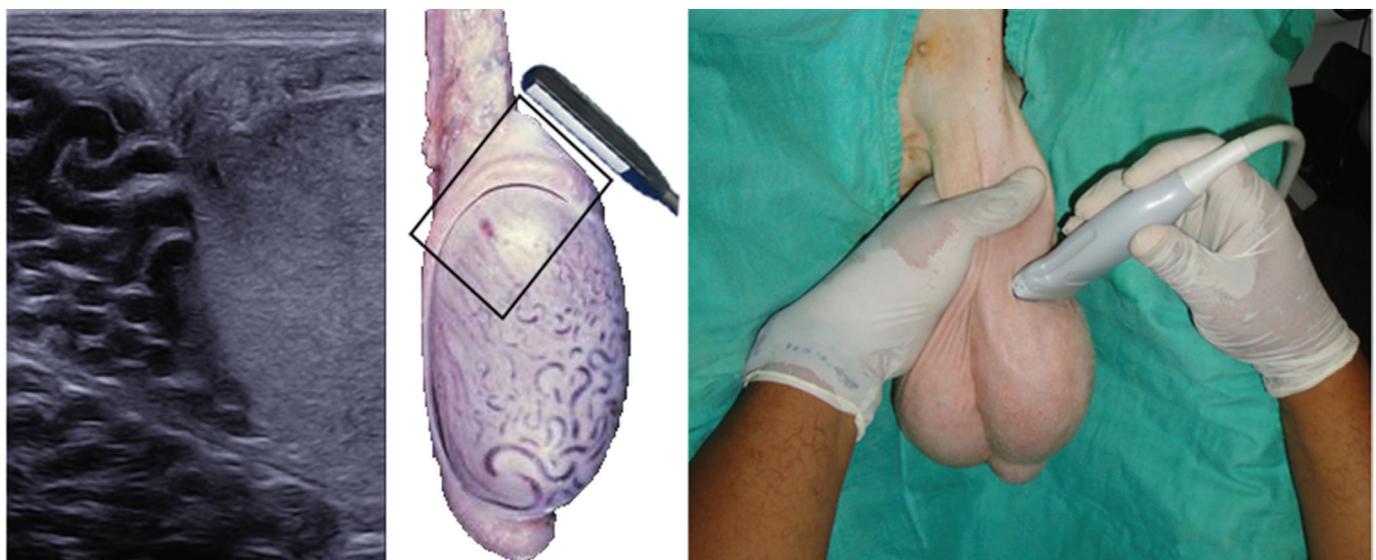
Oblique sagittal cut of the testis at the level of the epididymis head. This scan is clinically important because the pampiniform plexus frequently masks the head of the epididymis during ultrasonographic examination
